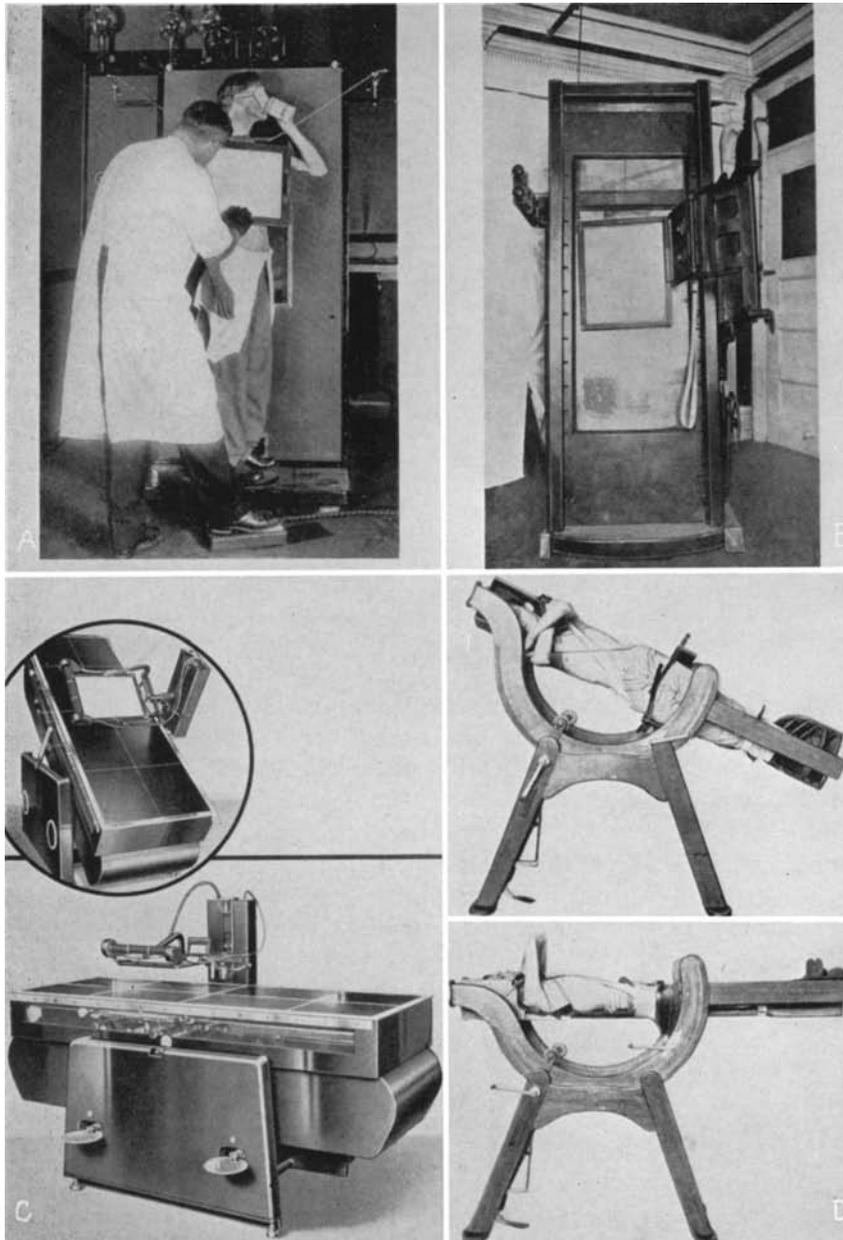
A. An old "vertical" fluoroscope, pictured on page 40 of the 1917 edition of Carman and Miller: "The Roentgen Diagnosis of Diseases of the Alimentary Canal." Note the similarity to existing types. Such improvements as have occurred have been purely mechanical and in no sense fundamental.
